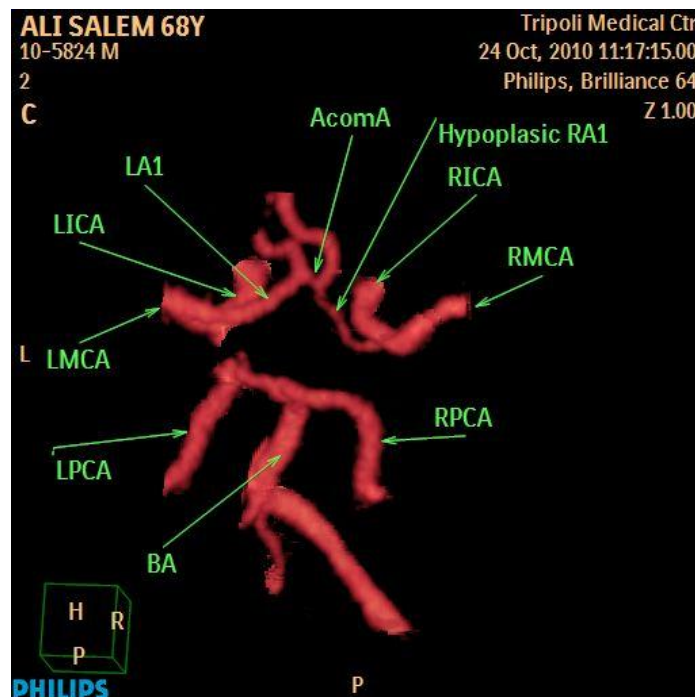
CTA shows hypoplastic RA1 and bilateral missing of PcomA.
